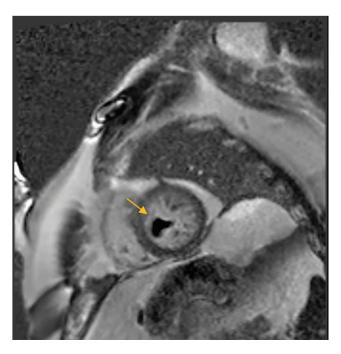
Cardiac magnetic resonance imaging with intravenous contrast in patient
